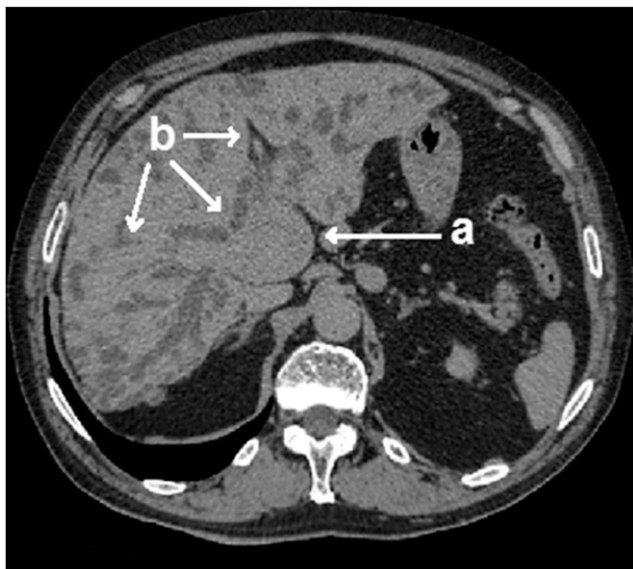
Case 2. Magnetic resonance imaging: signs of cholangiocarcinoma (sagittal view). Tumor in the right lobe of liver with bile hypertension, involving biliary cyst and defeat of regional lymphatic nodes. (A) Mass-like enlargement with unclear contours; (B) enlarged intrahepatic bile ducts.
